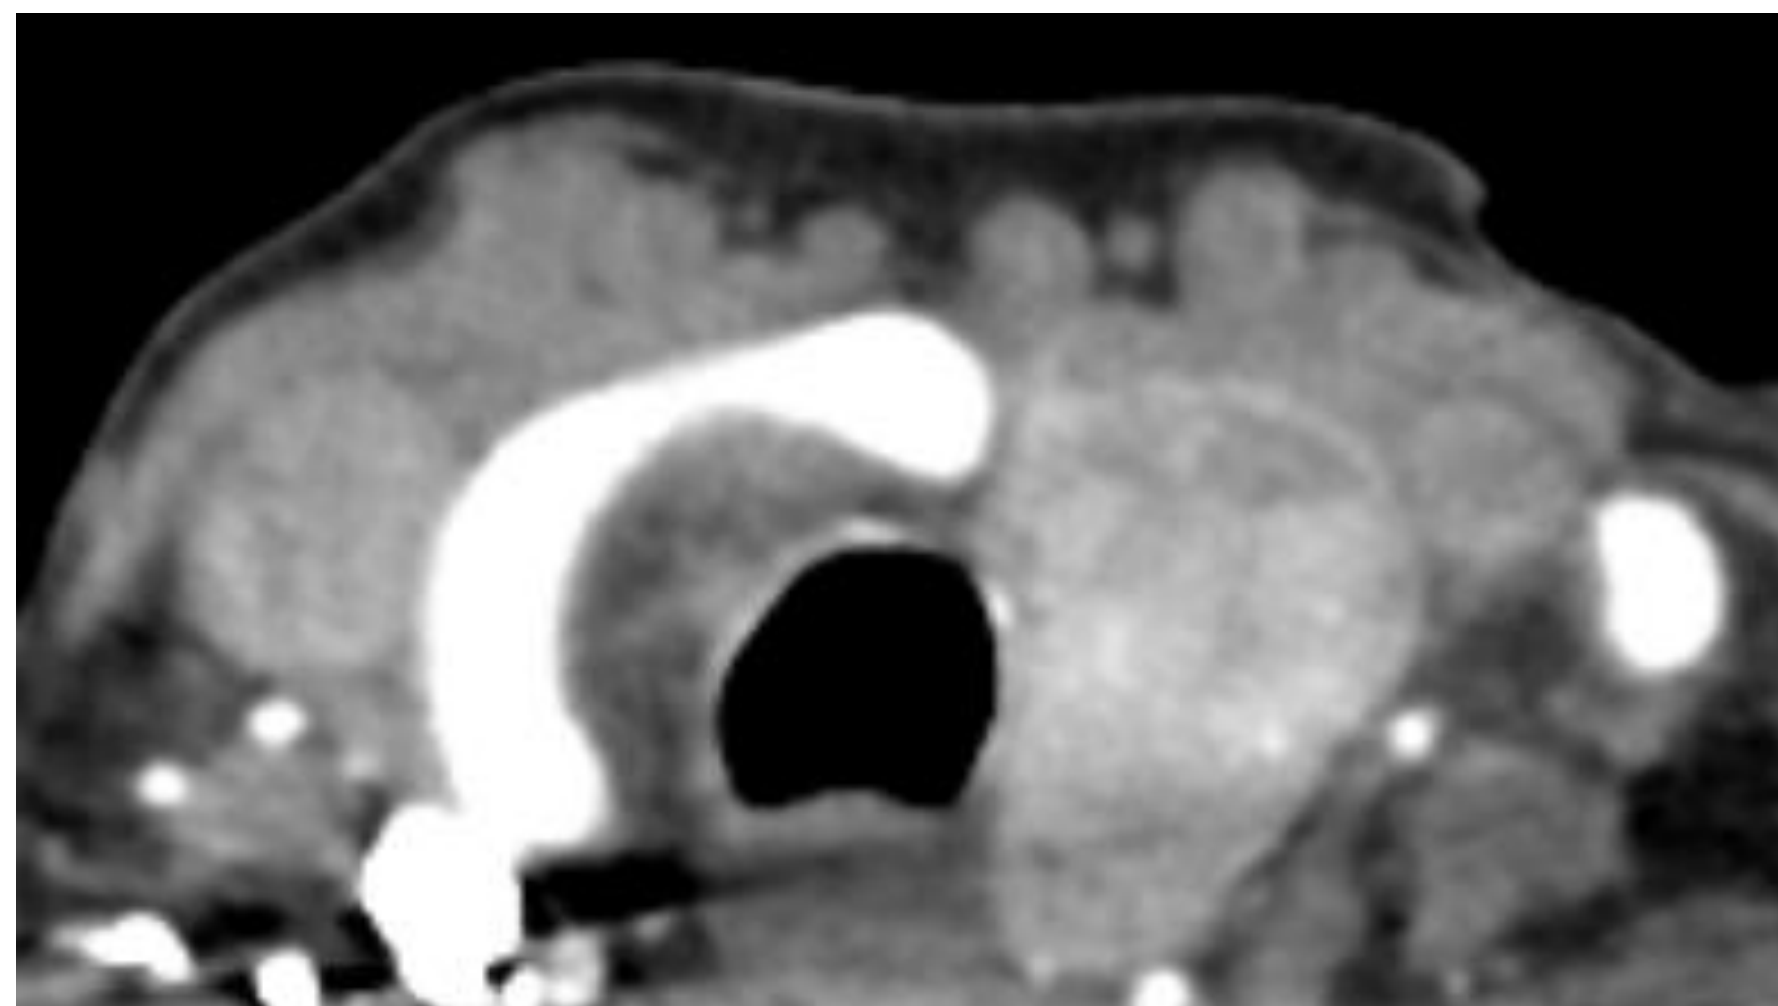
CT with contrast axial view showing innominate well into the neck and anterior to the thyroid.
